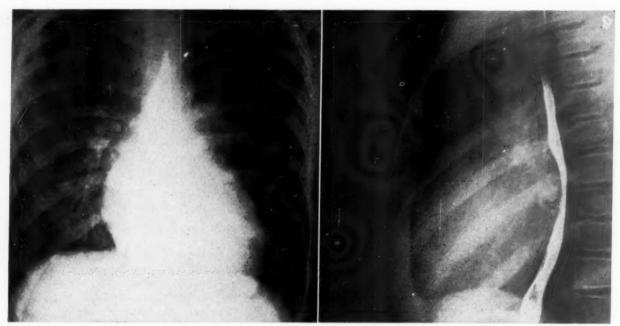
Case i. Posteroanterior and lateral roentgenograms of the chest. The transverse diameter of the heart is slightly increased. The increased oblique diameter of the heart and the obliteration of the posterior inferior cardiac recess indicate left ventricular enlargement. The posterior displacement of the esophagus in the region of the enlarged left atrium is evident. The major branches of the pulmonary artery are prominent.
